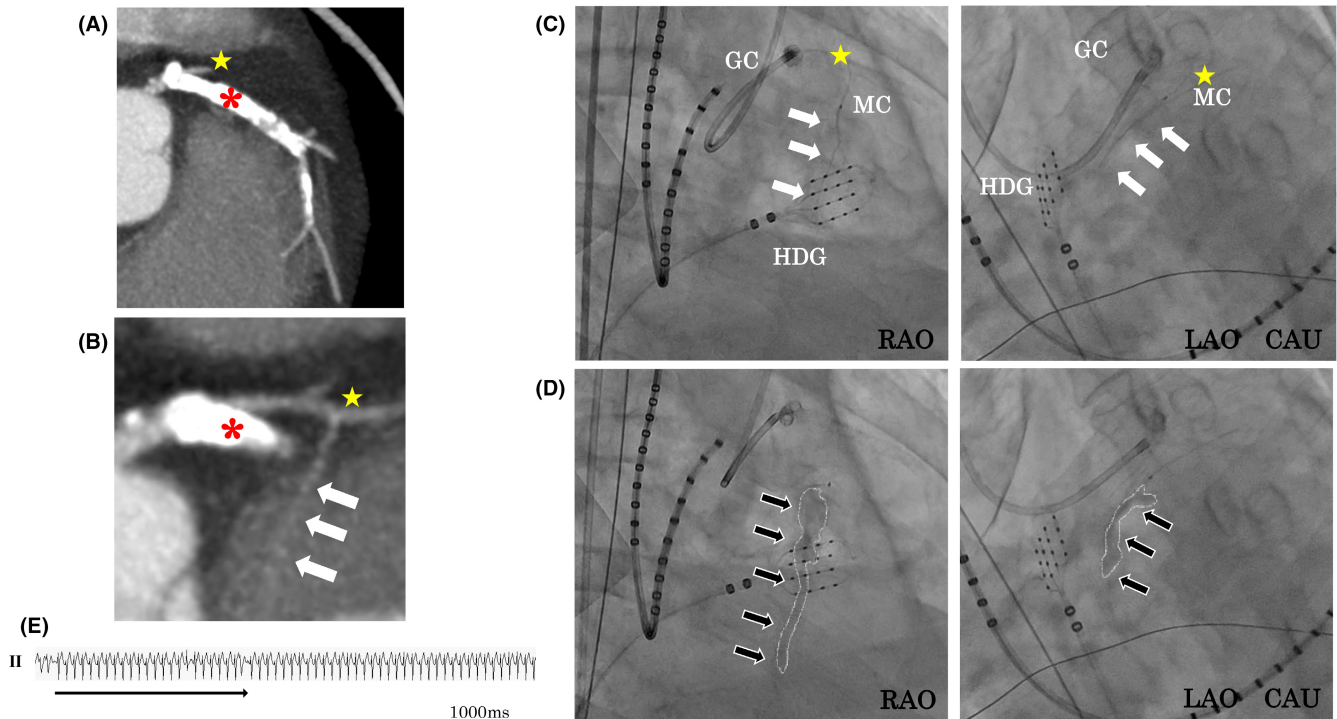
(A) No vessels return to the base of the ventricular septum from LAD (red asterisk). (B) Coronary CT shows the HL branch (yellow star) and LAD. The septal perforator (white arrow) is seen at the base of the ventricular septum. (C) Ethanol injection into the septal perforator. A guiding catheter was introduced into the left coronary artery, and selective contrast injection was administered via a microcatheter into the septal perforator (white arrow) branching from the HL branch (yellow star). (D) The contrasts did not shunt (black arrow). (E) Ventricular premature contractions were observed before ethanol administration but were suppressed after ethanol administration.
